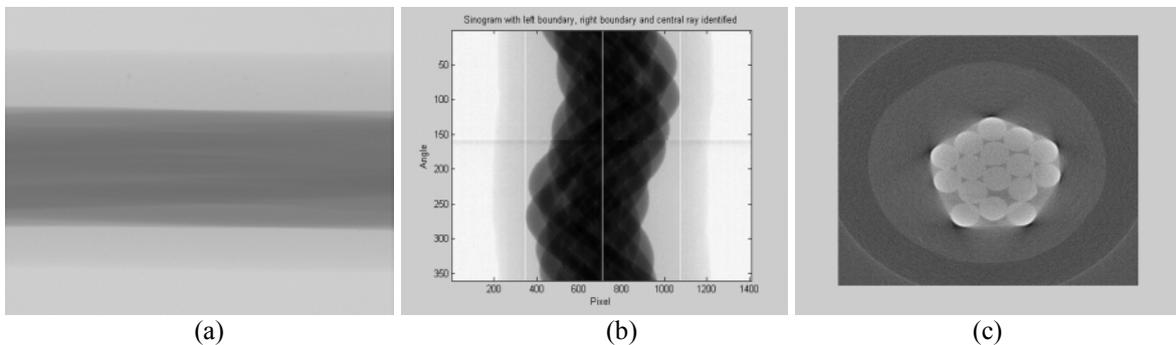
CT scan of a segment of electric wire bundle: (a) A 2D projection; (b) the sinogram of one slice with the two boundaries (black lines) and central ray (white line) identified; (c) the reconstructed image of the slice in (b)
